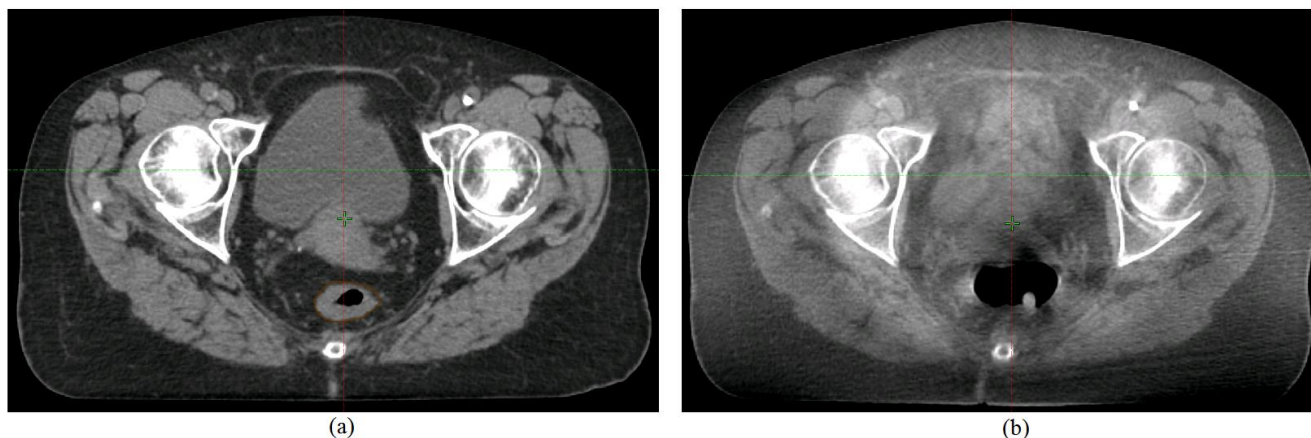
(b) An axial frame of the CBCT scan considered having too poor image quality for surrogate validation and (a) corresponding CT scan. The surrogate is delineated as the rectum on the CT scan and is indicated by a brown line.
